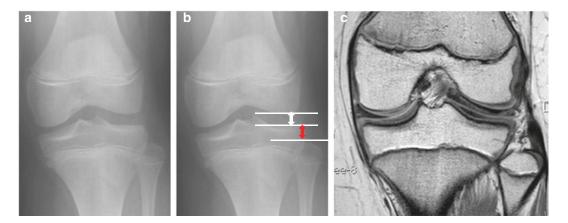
a Anteroposterior view seems to be normal radiograph of a 13-year-old boy. b Anteroposterior view shows widened lateral joint space (8.3 mm) and elevated fibular head (12.1 mm). c Coronal MR image shows discoid lateral meniscus of complete type
